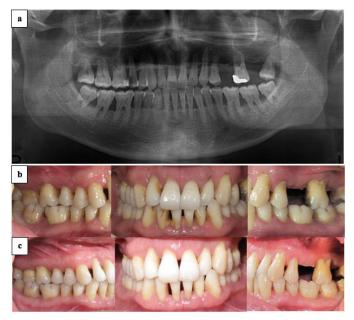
a) Baseline orthopantomography of patient-I. b) Baseline clinical appearance of patient-I. c) Clinical appearance of patient-I after 6 months.
